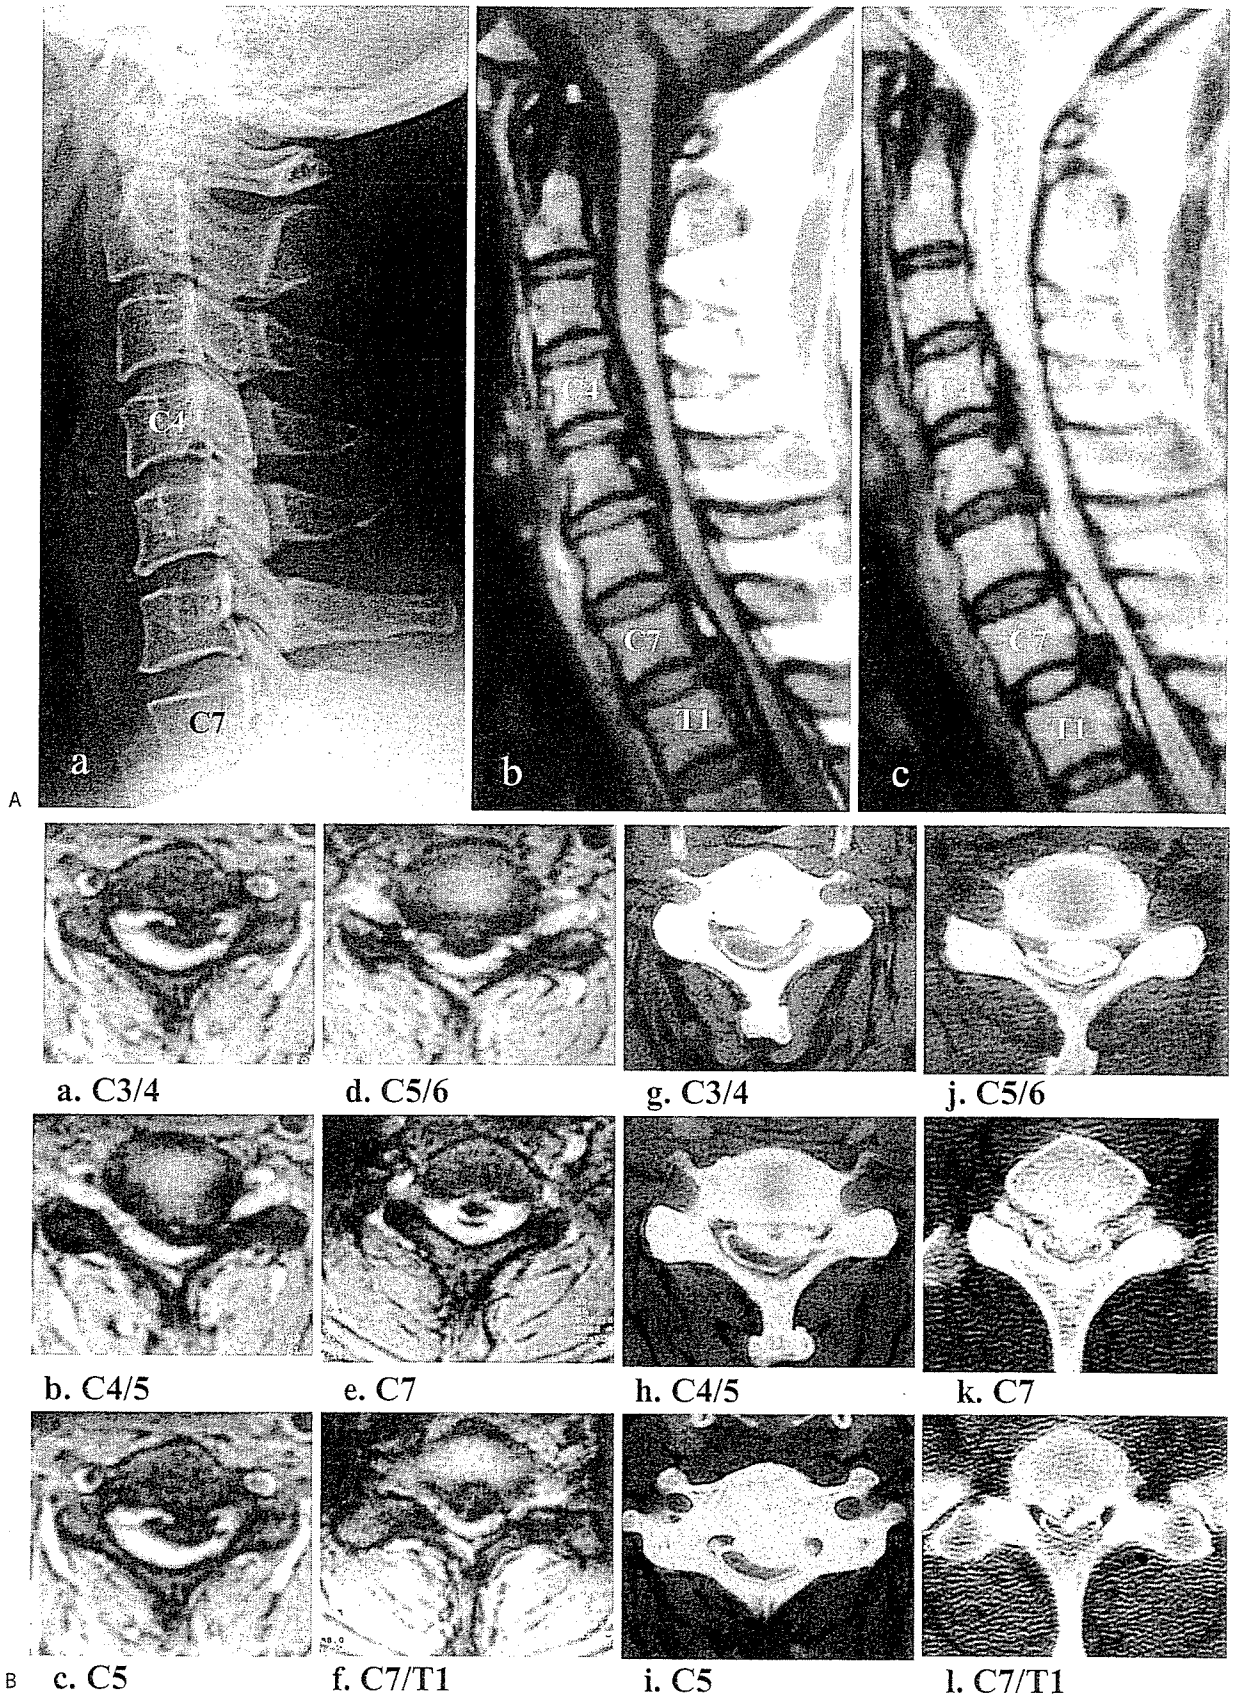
Mixed-type OPLL in a 46-year-old woman. A, a Radio-graph shows continuous-type OPLL extending over the C4, C5, and C6 levels. T1-weighted (b) and T2-weighted (c) sagittal magnetic resonance imaging (MRI) shows a low signal intensity mass from C3-C4 to C6 and the C7-T1 level. The spinal cord was severely compressed by the low intensity mass, as seen on the T1-weighted sagittal image. A high signal intensity area was seen in the spinal cord on T2-weighted sagittal image. B, a-f T2-weighted axial MRI. g-l CT-myelograms show severe compression in the spinal cord. Axial T2-weighted images show various sizes of low intensity mass from C3-C4 to C7-T1 (a-f), and the CT-myelograms show various types of OPLL at each cervical level (g-l)
